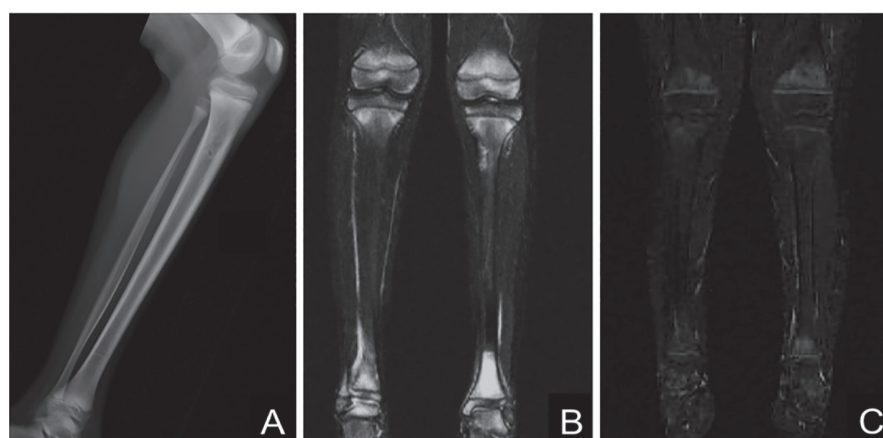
Periosteal hyperostosis of the left tibia on x-ray (A) and metaphyseal hyperintensity of the femurs and tibias on STIR MRI first (B) and after (C) one month of corticosteroid therapy.
